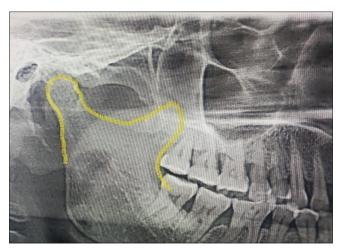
Orthopantomogram showing round condylar process
